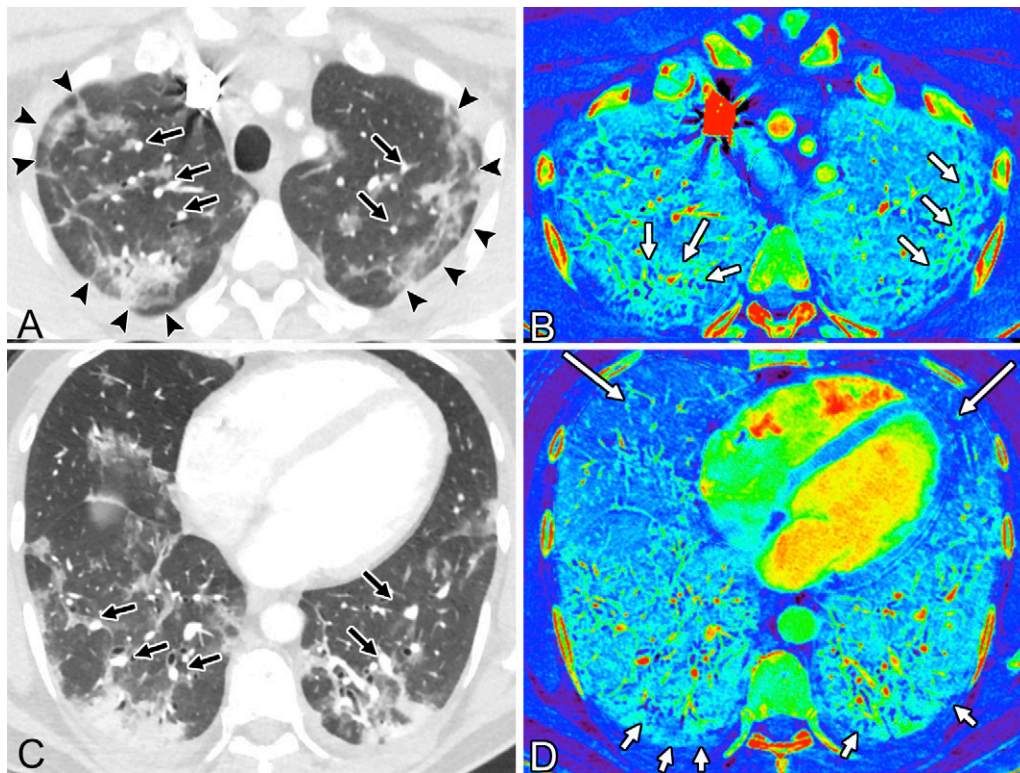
Images in a 45-year-old man who presented with cough and fever, requiring supplemental oxygen via nasal cannula, and was found to have coronavirus disease 2019. On day 5 of admission, patient underwent CT pulmonary angiography for acute shortness of breath, tachypnea, and an elevated D-dimer level. A, Contrast-enhanced CT pulmonary angiogram of the upper lungs shows multiple ground-glass opacities and consolidation with a peripheral predominance; several peribulbar bands of consolidation suggest an organizing lung injury pattern (arrowheads). Subsegmental vessels supplying regions of opacity are dilated (arrows). B, Corresponding iodine map image shows increased perfusion of some areas of opacity (arrows). C, Axial CT image as part of the same examination shows additional peripheral ground-glass opacities and consolidation in the lower lungs, with enlarged vessels within and supplying regions of lung with opacity (arrows), while vessels in the anterior lungs are smaller in caliber with relatively lower regional attenuation of the anterior lungs. D, Corresponding iodine map image shows increased perfusion to the posterior lower lobes in general, decreased perfusion of the anterior lungs (long arrows), and small perfusion defects corresponding to posterior areas of opacity seen in C (short arrows).
